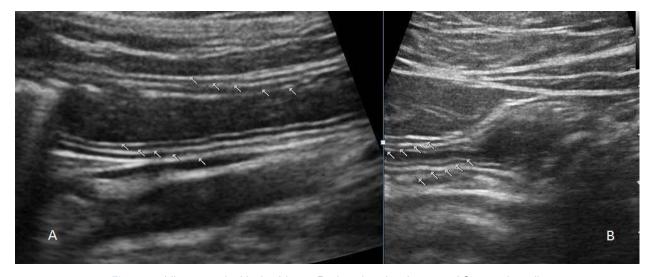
Ultrasound with the Linear Probe showing Layers of Stomach wall
